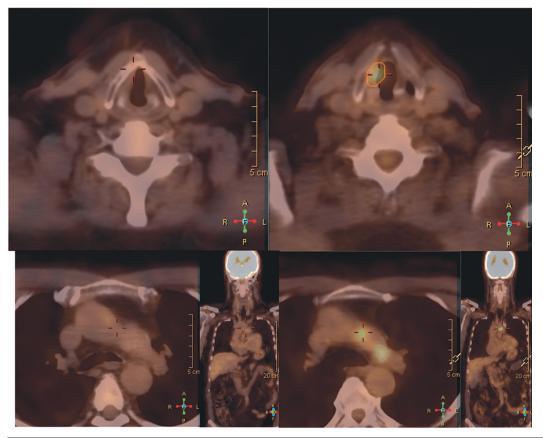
Comparison of the whole-body FDG-PET/CT imaging from July 2019 (under treatment with prednisolone 20 mg/day; panels A, C and D) and May 2020 (under treatment with prednisolone 5 mg/day; panels B, E and F) at the level of the vocal cords. showing de novo increased FDG uptake at the right vocal cord with a maximum SUV of 5.45 (panel B), and at the aortopulmonary window (panels E and F), showing two foci of de novo increased FDG uptake with maximum SUVs of 5.89 and 5.44.
